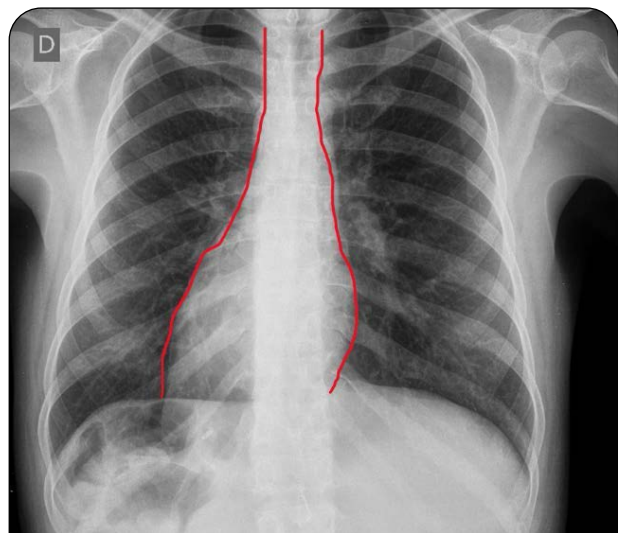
Anteroposterior radiography of the thorax yields cardiac silhouette on the right hemithorax, with the apex in the same direction.
